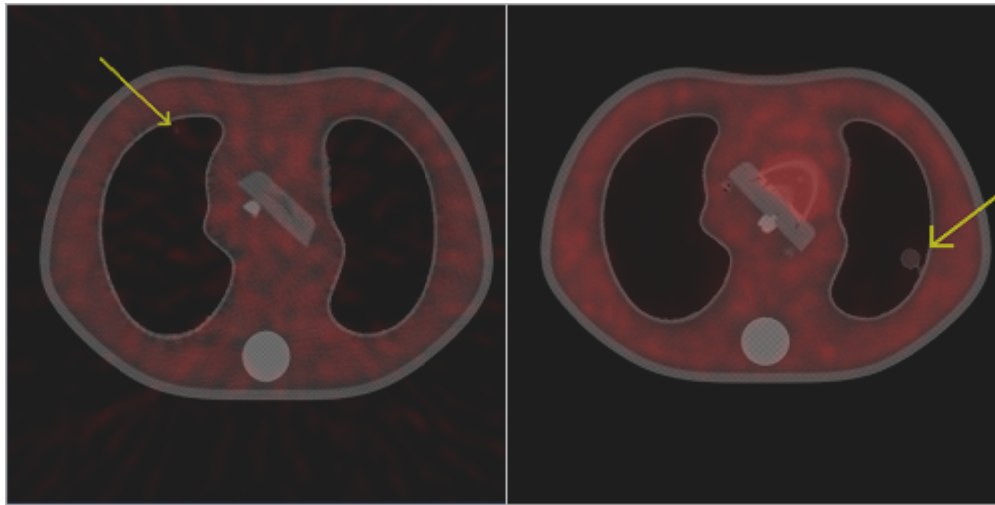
PET/CT images demonstrating lesion visibility vs. lesion size, TBR, acquisition mode, and reconstruction algorithm: (left) small lesion with high TBR acquired in 3D mode reconstructed with FBP; (right) large lesion with low TBR acquired in 2D mode reconstructed with OSEM. The lesions are marked by yellow arrows.
